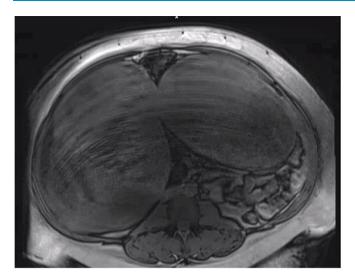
An MRI scan image demonstrating two large dominant masses filling the abdomen and pelvis, giving the impression of the leiomyomas. Axial T1-weighted MRI images of the pelvis reveal findings of two rounded heterogeneous leiomyomas, each one originating from the uterus.
